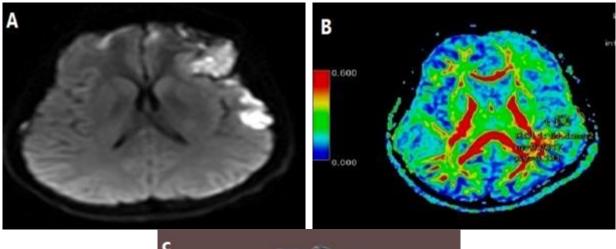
A male patient aged 57 years, there was a medical history of hypertension and diabetes, the patient was presented with right side weakness and aphasia. (A) and (B) large infarction lesion was seen in the left Broca's area, area of restricted diffusion in (DWI) and color ADC map. (C) Fractional anisotropy (FA) map showed: disruption of the left FA fibers (Left arrows) in comparison to right side, this patient had AHS of 3.55.
